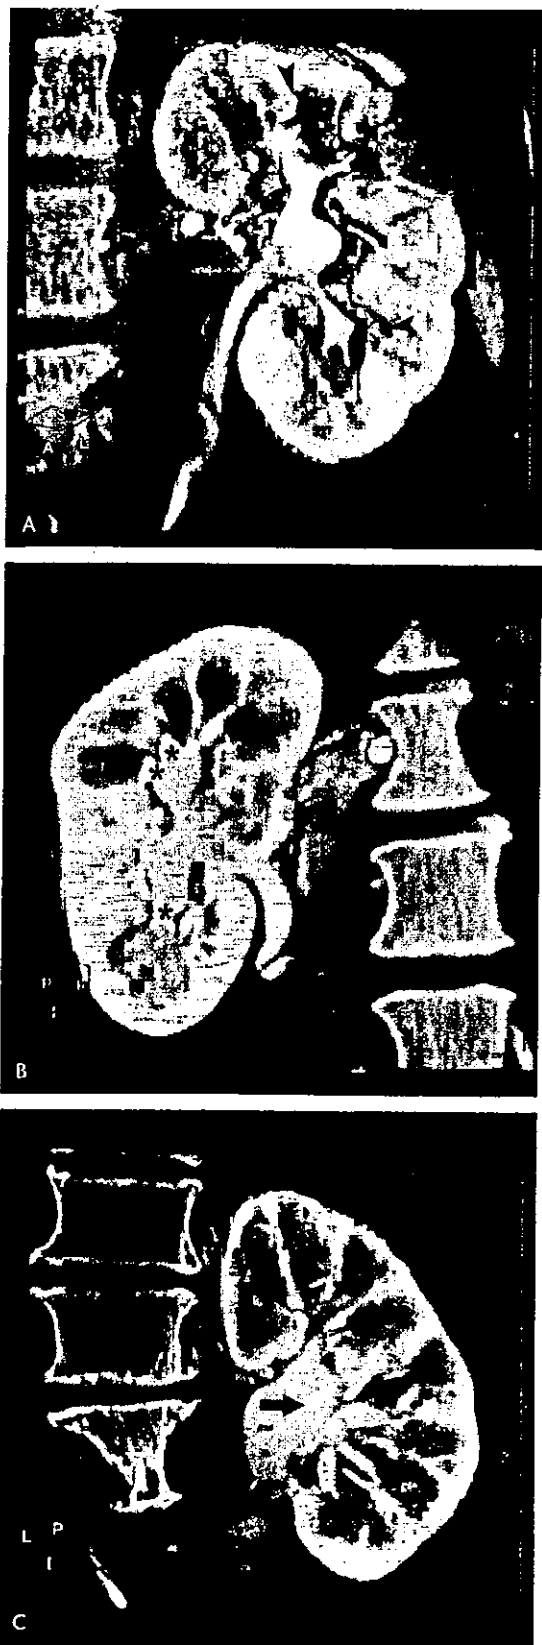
Selective intra-arterial volume-rendered 3-dimensional computed tomography angiographic images demonstrated different visualization scores for the peripheral renal veins in 4 patients: score of 5 (A), score of 4 (B), score of 3 (C), and score of 2 (D). The numbers in the figures (V1–V5) show the order of the renal venous branches. C, Double renal veins were detected (arrows).
